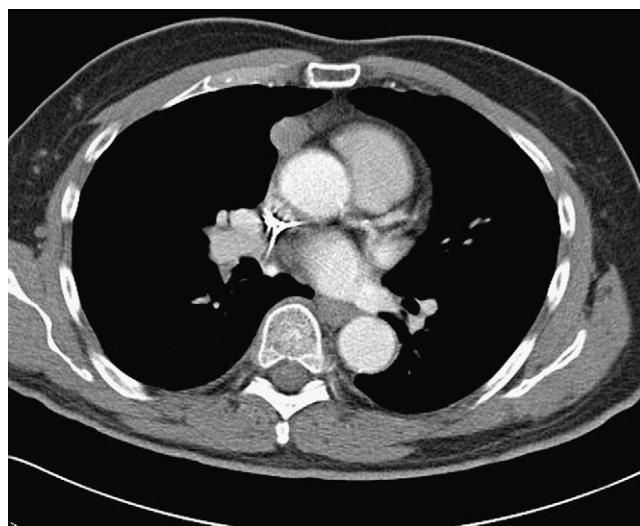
CT scan of chest done with 100 mL Ominpaque-240 contrast media and 5 mm image cuts. There is a 20 × 15 mm anterior mediastinal soft tissue mass inferior to the expected position of the thymus and directly right anterior to the ascending aorta.
